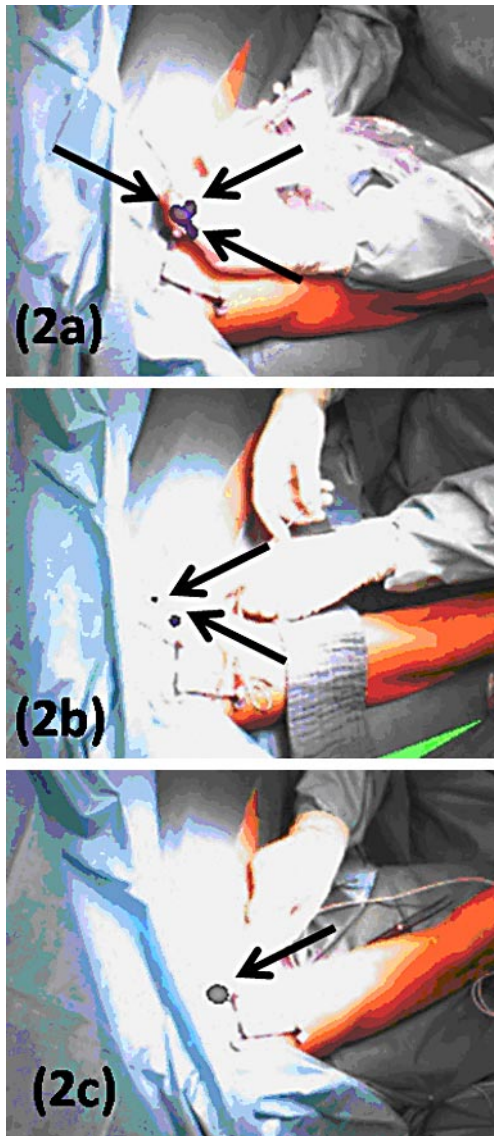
Intraoperative freehand SPECT image overlaid over video of patient showing the same topology as preoperative scintigraphy before incision (a) and then the successive biopsy of the SLNs (b, c).
